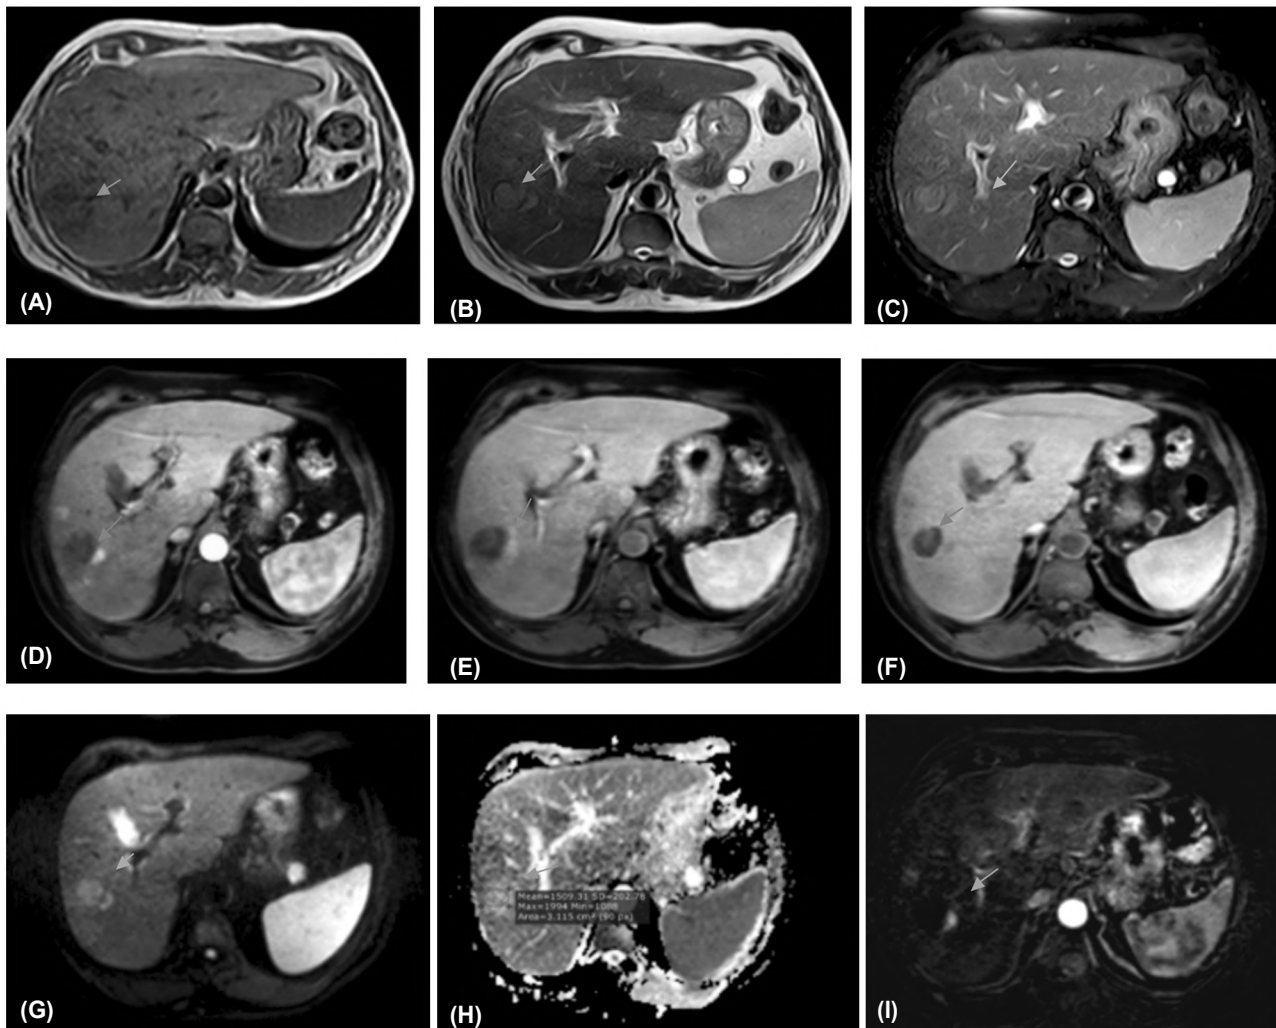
Male patient 66 year old, post TACE of right hepatic lobe HCC, follow-up 1.5 month, showed low SI in T1WIs (A), iso intense in T2WIs (B) and SPIR WIs (C). It showed peripheral focal enhancement in the arterial (D) with wash out of contrast in porto-venous phases (E) and the delayed phase (F). It showed mild restricted diffusion at DWIs (G) and iso-intense in ADC map (H) with positive enhancement in the subtraction dynamic MRI (I).
